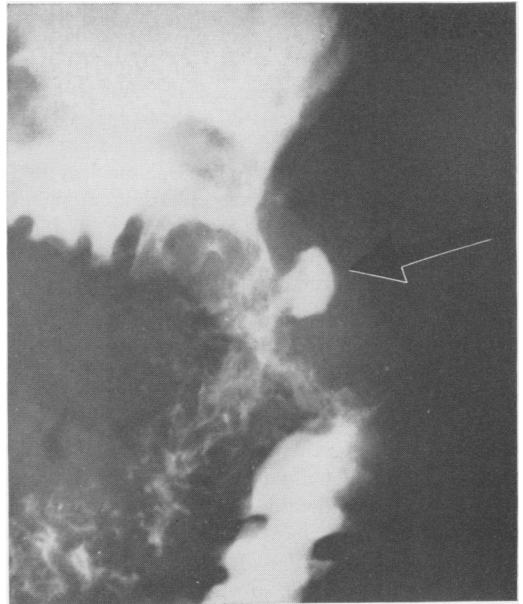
Photograph of x-ray study demonstrating the third jejunal ulcer.
